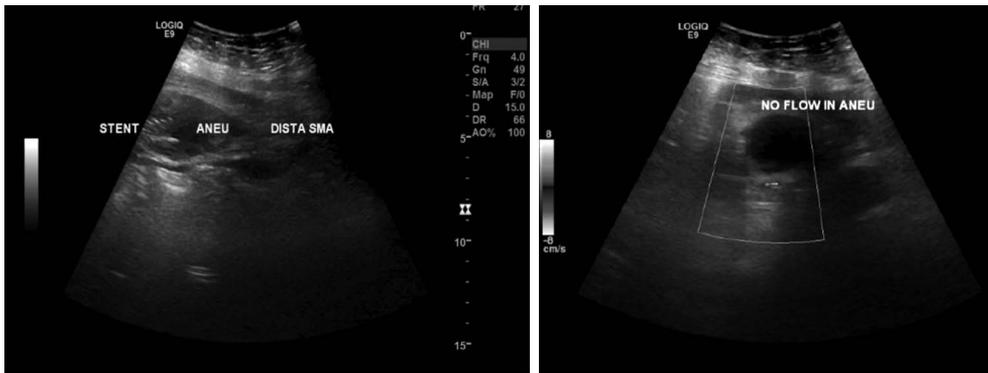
Abdominal color Doppler ultrasonography showing no flow in ligated superior mesenteric artery pseudo-aneurysm after surgery.
